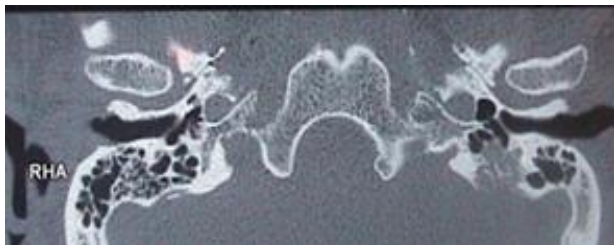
CT scans showing left endolymphatic sac tumor.
